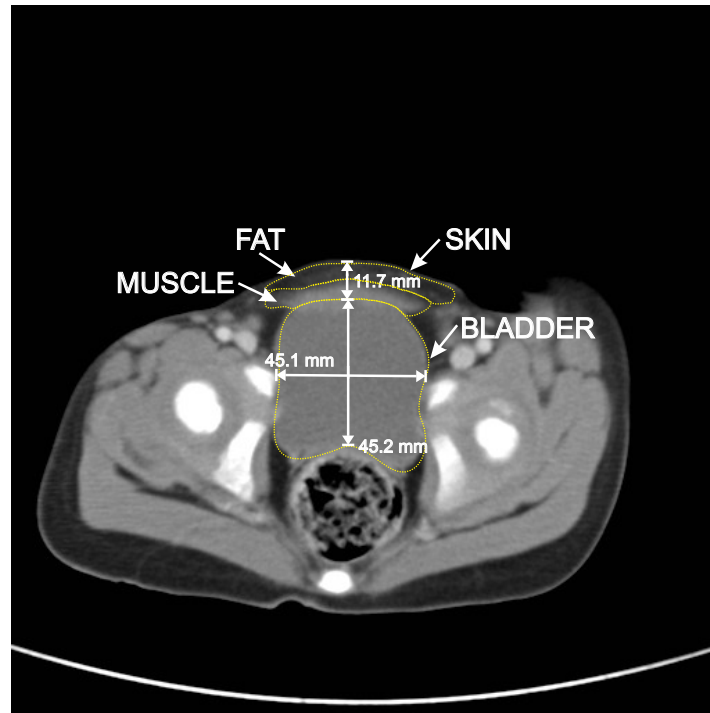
Axial CT scan of 3 years old child with segmentation of intervening tissue and bladder.
